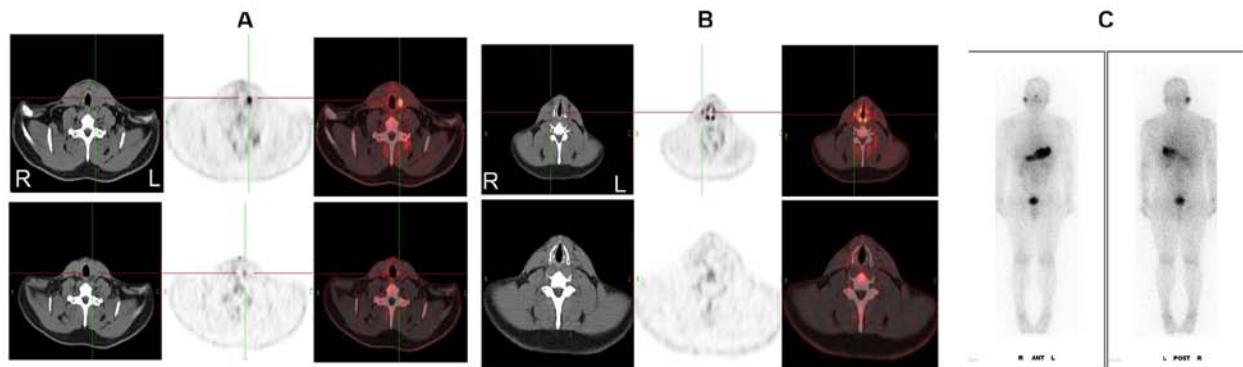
A 24-year-old male patient with papillary thyroid carcinoma with mLNs. The LNs detected by CT exhibited a spherical shape and a homogeneous density, which revealed hypermetabolic LNs in the (A) left side of the neck and in the (B) right side of the neck. The standardized uptake values of the LNs on the PET/CT images before (upper images) and after (lower images) ^{131}I therapy were 5.7, 3.5, and 3.0, 1.1, respectively. (C) ^{131}I whole-body scan image revealed no ^{131}I accumulation in the two mLNs. The lesions achieved a partial response (LN in the left neck) and complete response (LN in the right neck), respectively. mLN, metastatic lymph node; LN, lymph node; PET, positron emission tomography; CT, computed tomography; ^{131}I , iodine-131.
